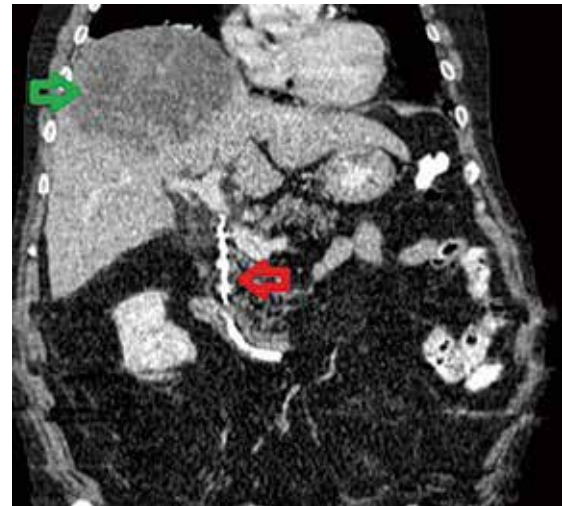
Hepatic abscess and stent in CBD. CT of the abdomen depicting a 17x11.3x7.7cm hepatic abscess in the right hepatic lobe and a stent in CBD causing slight dilation of intra-hepatic bile ducts. The green arrow is demonstrating the hepatic abscess, whereas the red one is depicting the stent in CBD.
